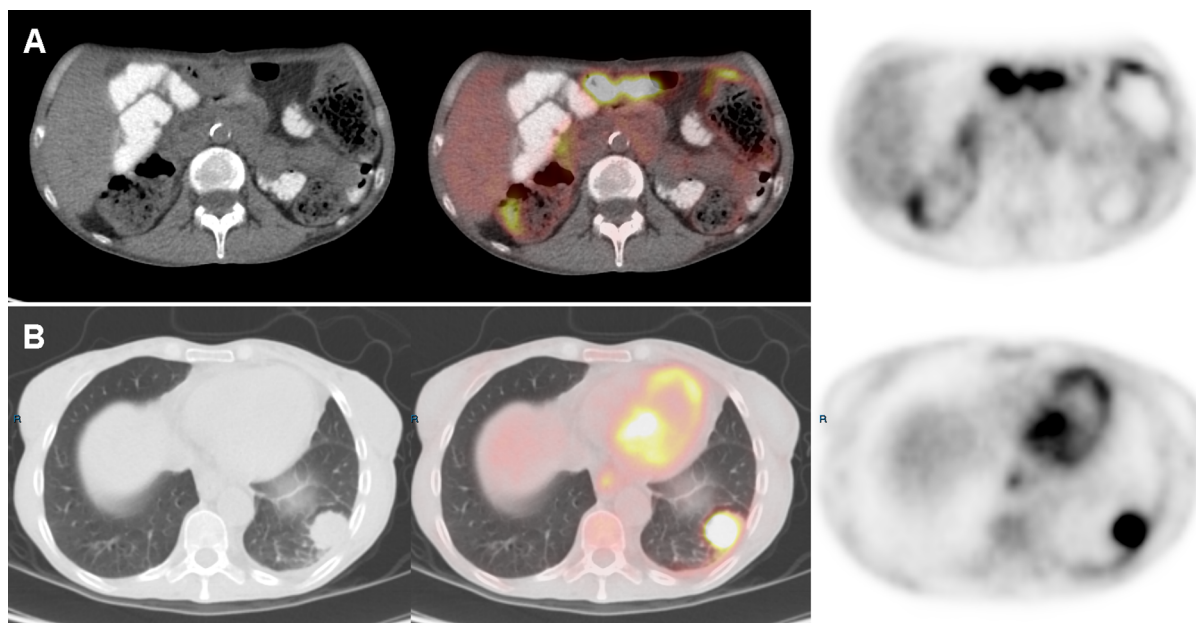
Patient 3. Axial view CT, FDG-PET/CT fusion and maximum intensity projection images: a Increased pathological FDG uptake in a mass lesion in the transverse
